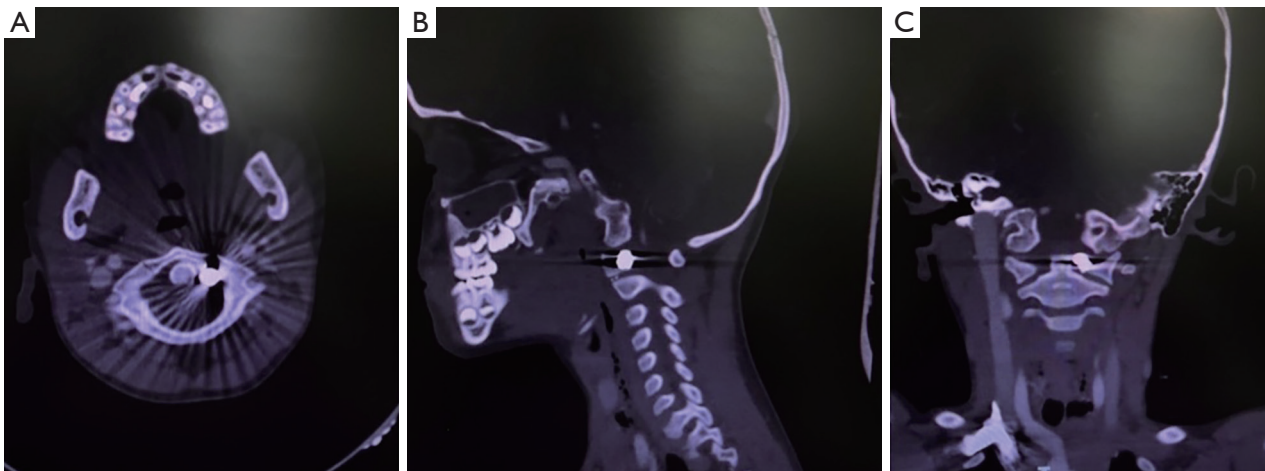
(A) Axial section, (B) sagittal section, and (C) coronal section of cervical CT showing that the pellet is at the C1 level. CT, computed tomography.
